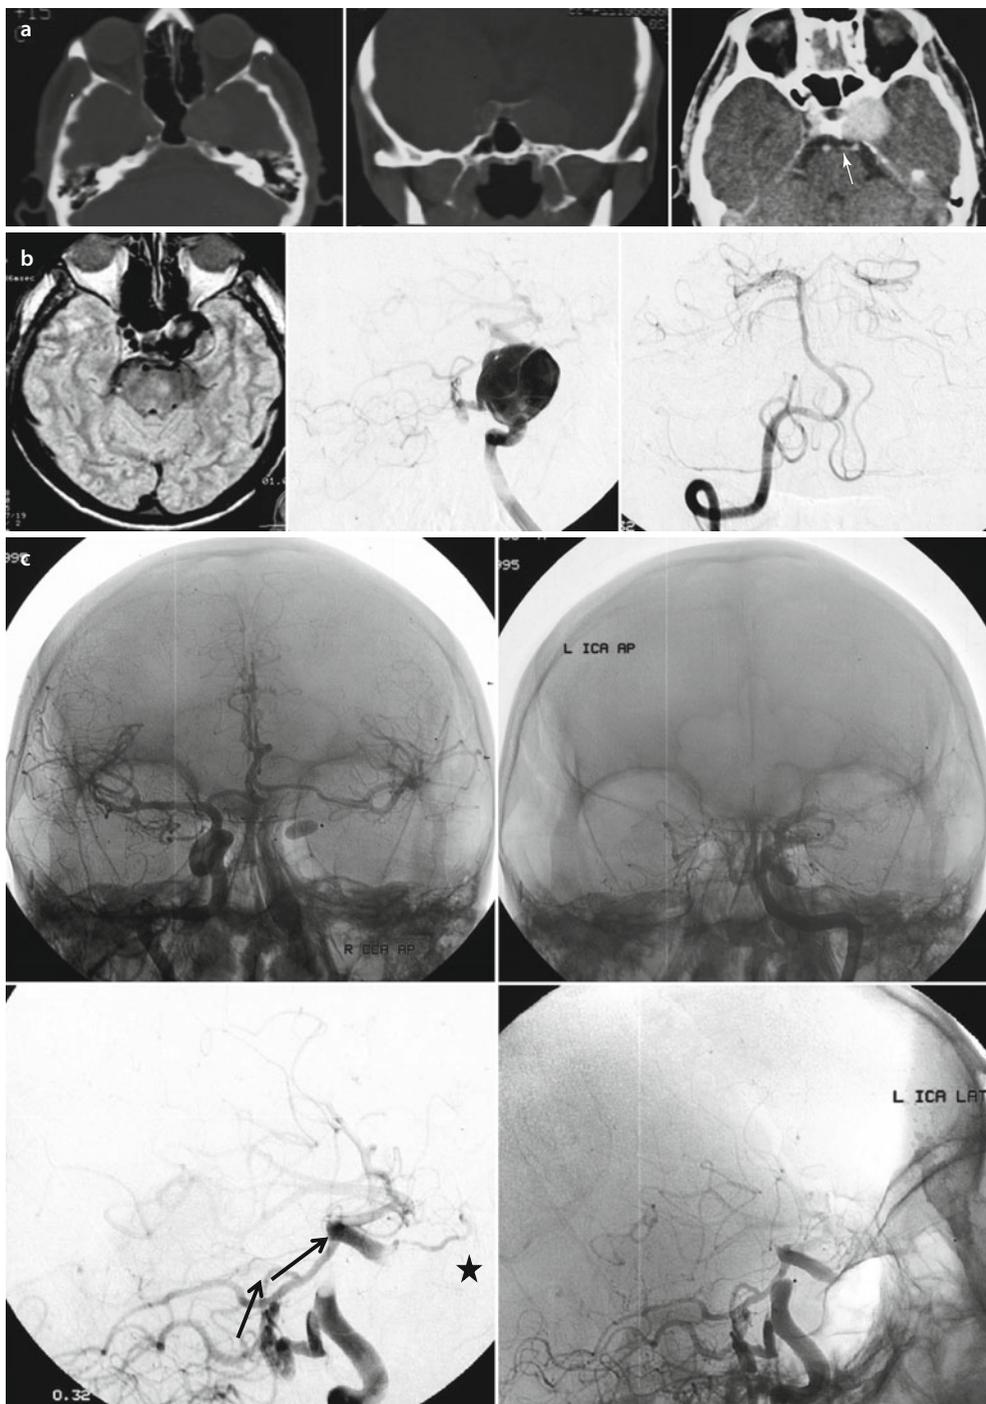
A 62-year-old man presented with headaches and ophthalmoplegia. (a) NECT and CECT images reveal a giant cavernous aneurysm remodeling and scalloping the adjacent sphenoid bone. Also, note on CECT, there is an artery connecting ICA with basilar artery (*arrow*). (b) On January 1995, MRI and cerebral DSA reveal a 30 × 28 mm-sized, giant left cavernous aneurysm. A persistent trigeminal artery (PTA) is seen connecting the cavernous ICA to basilar artery. The left vertebral artery is absent and the vertebral-basilar system is hypoplastic. (c) A balloon occlusion test was well tolerated, and the patient was treated with PVO using a detachable balloon deployed just above the trigeminal artery in the ICA. Immediate postprocedural ICA angiogram reveals opacification of the posterior circulation through the PTA. The posterior circulation via PCoM opacifies the left supraclinoid ICA. Note the intact ophthalmic artery (*star*). *Arrows* indicate the direction of blood flow
